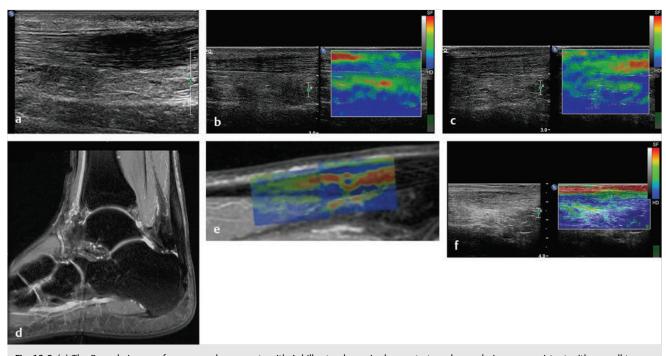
(a) The B-mode image of a runner who presents with Achilles tendon pain demonstrates a hypoechoic area consistent with a small tear or tendonosis. (b) The SE image just above the hypoechoic area demonstrates the tendon is stiff (blue) but is softer as it nears the hypoechoic area. (c) Over the area of hypoechogenicity the tendon becomes very soft (red). (d) The corresponding T2-weighted magnetic resonance (MR) image taken at the same time demonstrates an area of increased signal at the site of hypoechogenicity on US. (e) Fusion of the strain elastography (SE) image and T2-weighted MR image confirms the areas of abnormality on both modalities are identical. After two months of treatment the patient returned for (f) a repeat SE image that shows the tendon has returned to near normal with only a small area of softness (green).
